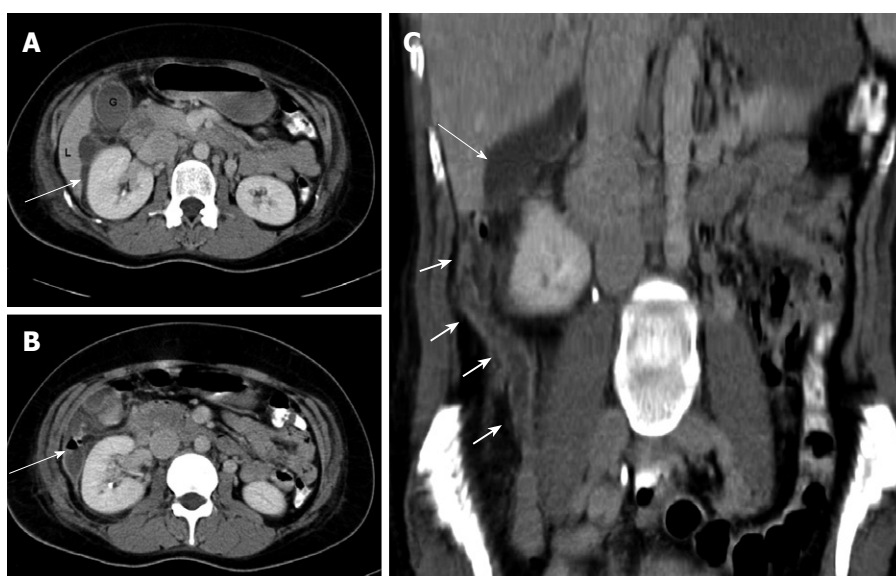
A 31-year-old woman presenting with right hypochondrial pain and a clinical diagnosis of pelvic inflammatory disease and right pyelonephritis. A: Contrast-enhanced CT scan showing fluid collection (arrow) in the subhepatic region, extending anteriorly to the gallbladder fossa with inflammatory stranding; B: Note the air fluid level in the collection adjacent to the right kidney; C: Coronal reconstruction showing the long thickened and inflamed appendix (short arrows) reaching the subhepatic region, and the subhepatic collection (arrow) is seen extending more cranially.
